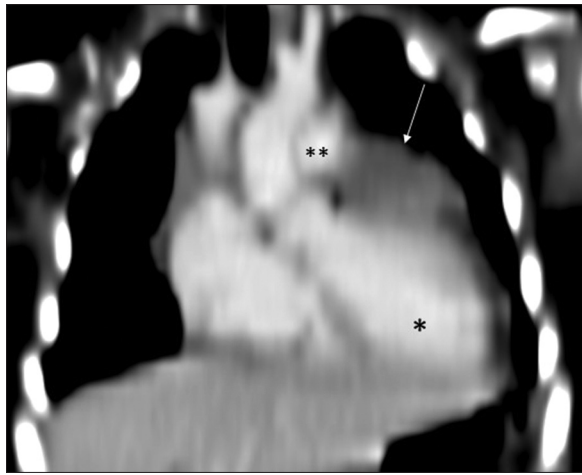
Postoperative coronal computed tomography residual pericardial mass (arrow) at base of left ventricle (*), adjacent to pulmonary artery ()
